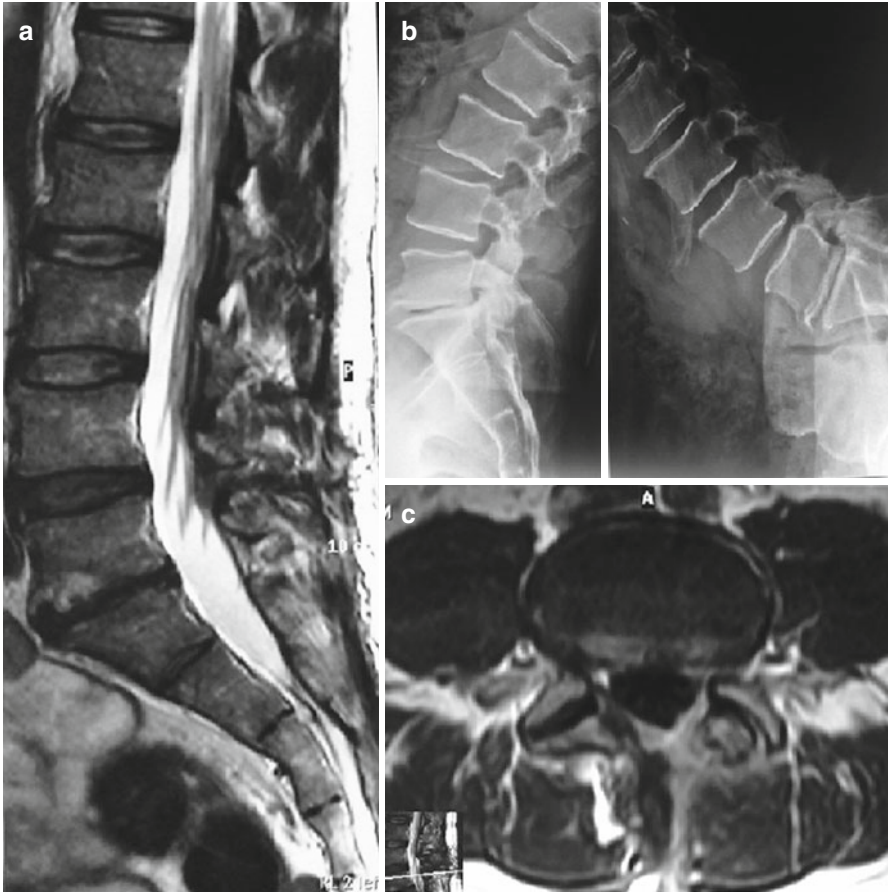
Same case as Fig. 16.2. Postoperative MRI. Sagittal (a) and axial (c) T2-weighted images that show complete excision of the cyst and preservation of the facet joint. Maintenance of vertebral stability is demonstrated by dynamic X-rays at 2-year follow-up (b)
